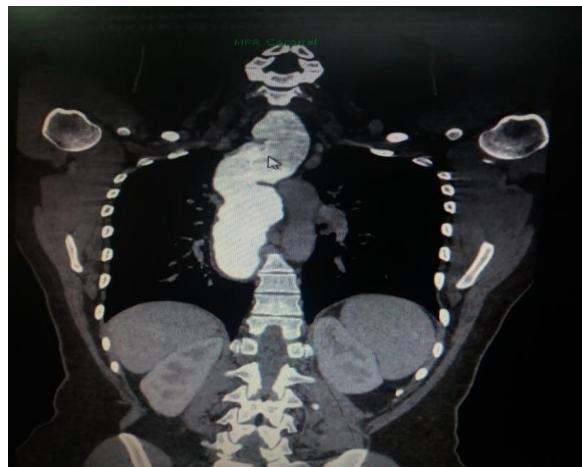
Abdominal CT scans: tortuous dilatation of the body of the esophagus up to 50 mm in diameter with a tapered aspect of the cardia
